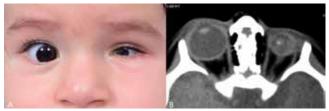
(A) Left microphthalmos (B) Axial CT demonstrates smaller left eye and orbit in comparison to the contralateral side.
